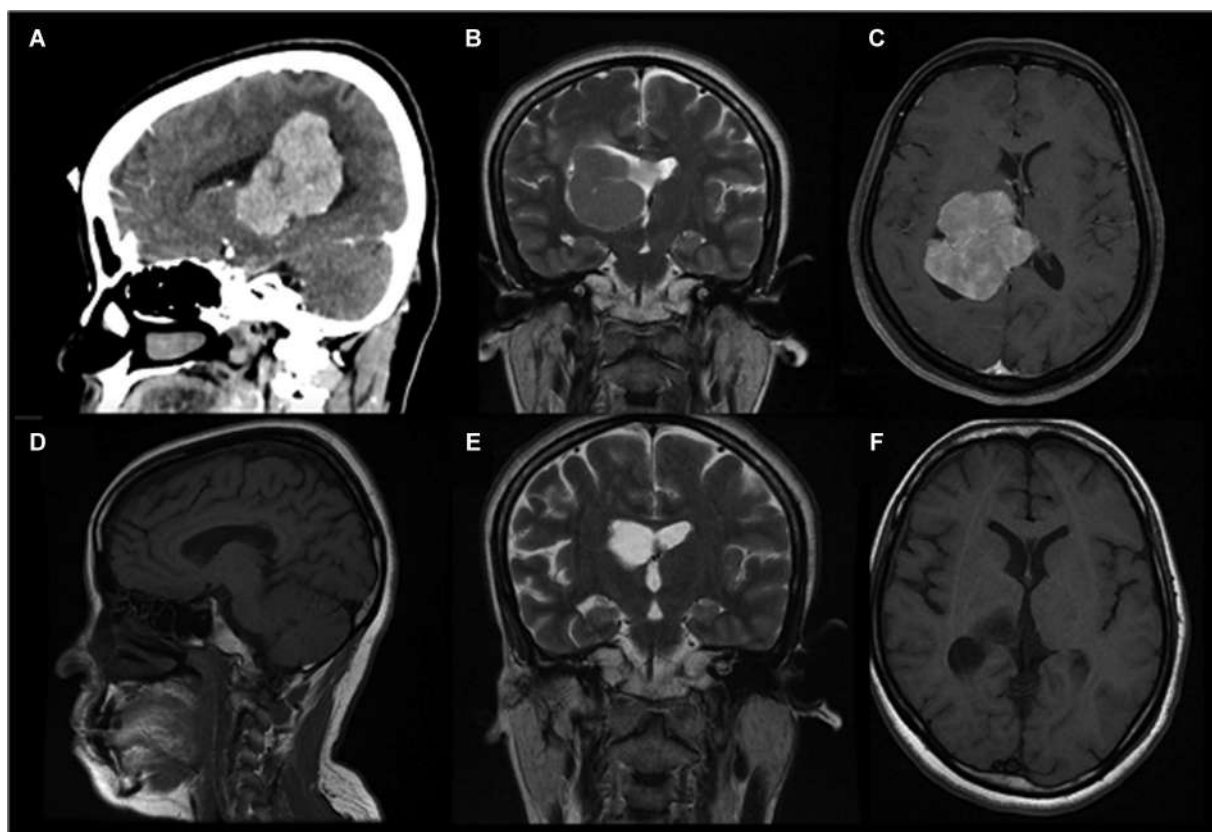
Preoperative sagittal enhanced brain CT (A) scan. Preoperative MRI scans with coronal T2-weighted (B) and axial gadolinium-enhanced T1-weighted (C) images showing an expansive lesion in the right atrial region of the lateral ventricle. (D-F) Postoperative MRI scans.
